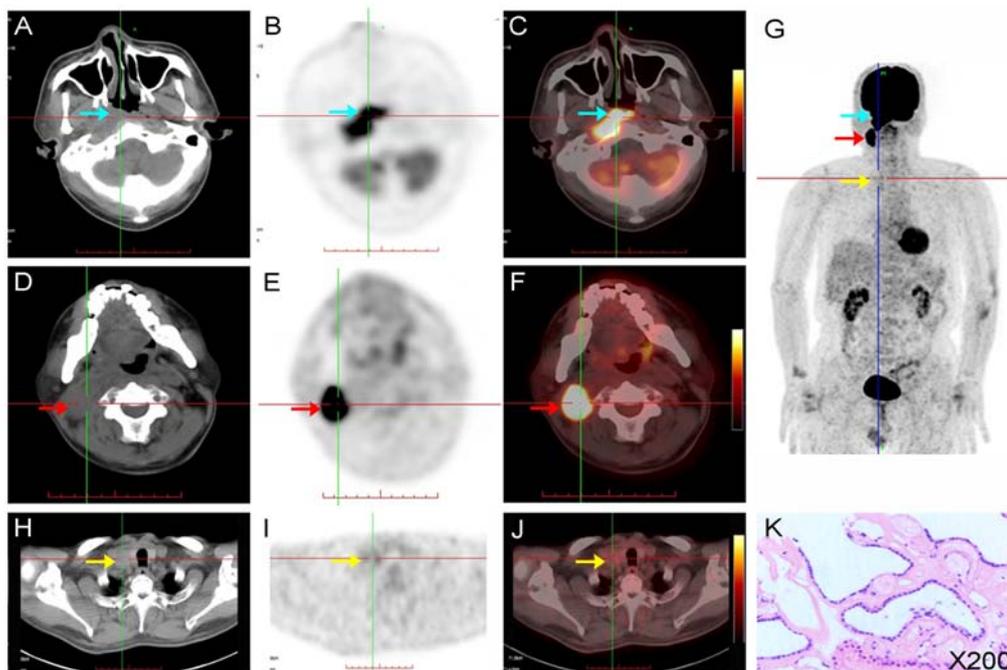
From left to right were plain CT, PET, PET and CT fused image. The blue arrow showed higher ¹⁸F-FDG accumulation in the nasopharyngeal lesion (A-C). The red arrow showed higher ¹⁸F-FDG accumulation in the right upper neck (D-F). The yellow arrow showed no uptake of ¹⁸F-FDG (H-J) in the right supraclavicular region. Figure G showed the coronal maximum intensity image. Pathological diagnosis confirmed as differentiated thyroid tissue (K).
